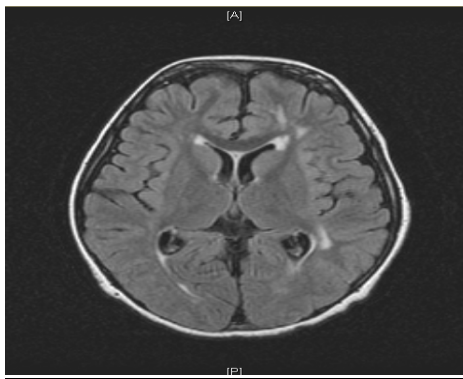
(a): MRI of the Brain FLAIR Sequence Axial View Showing Hyperintensities in the Cerebral White Matter
